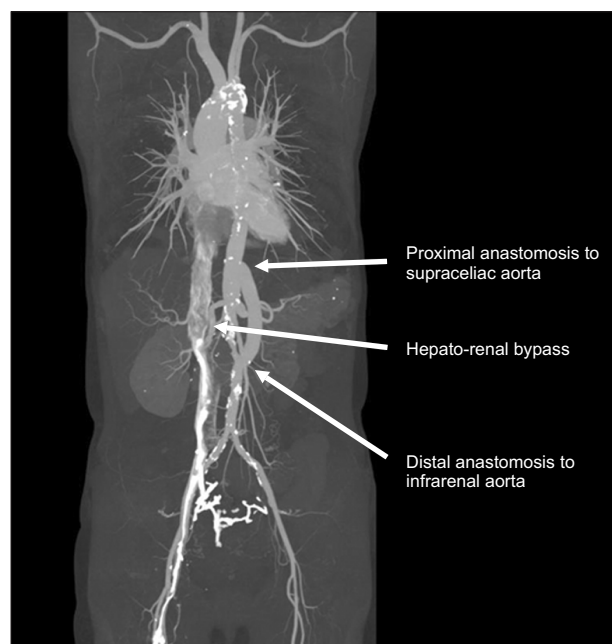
Postoperative computed tomography angiography showed supraceliac aortic-infrarenal aortic bypass and hepato-renal bypass.
